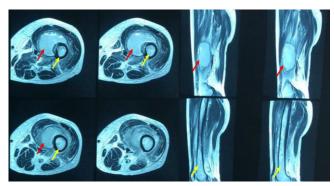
MRI images of left thigh demonstrating features of femur osteomyelitis with huge periosteal collection (red arrows). Femur marked with yellow arrows
